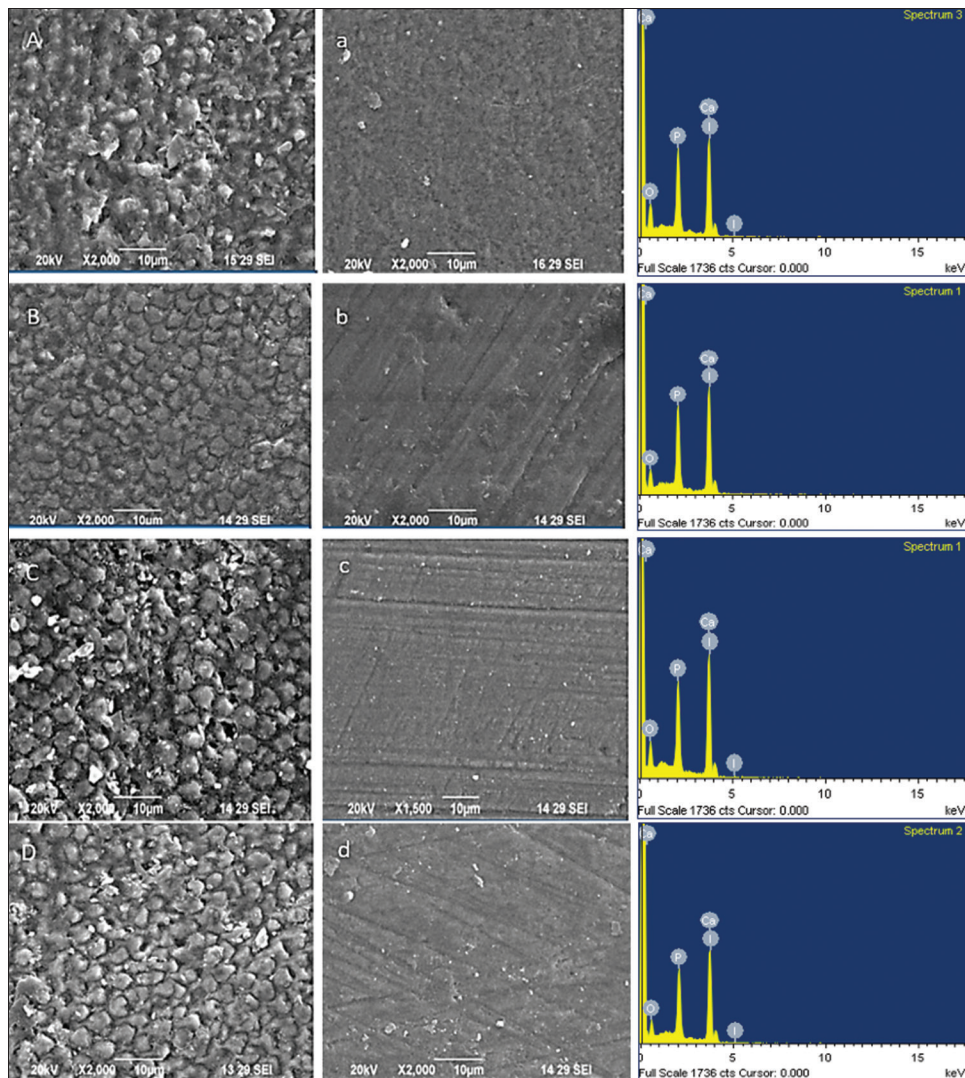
SEM of demineralized (uppercase) and remineralized (lowercase) enamel with energy dispersive X-ray analysis for casein phosphopeptide-amorphous calcium phosphate fluoride (A and a), Tricalcium Phosphate Fluoride (TCP-F) (B and b), calcium sucrose phosphate (C and c) and P11-4 (D and d)
